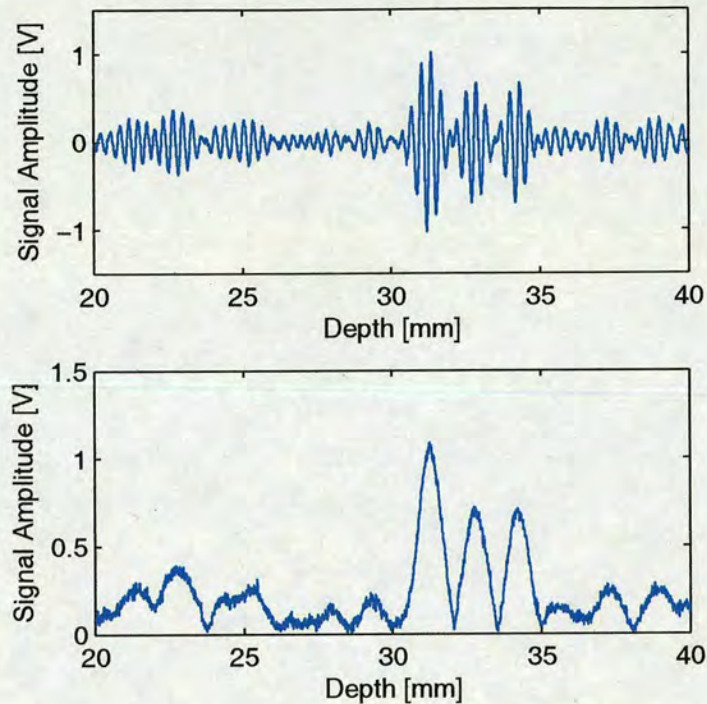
Example of an A-Mode scan. The top portion shows the original signal, as would be seen on an oscilloscope, while the lower part shows a plot of the envelope of this signal, as would be seen on an A-Mode ultrasound machine.
